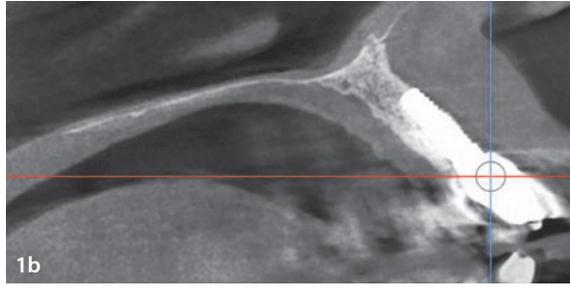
A CBCT scan revealed that the implant was positioned buccally, outside of the alveolar housing.
